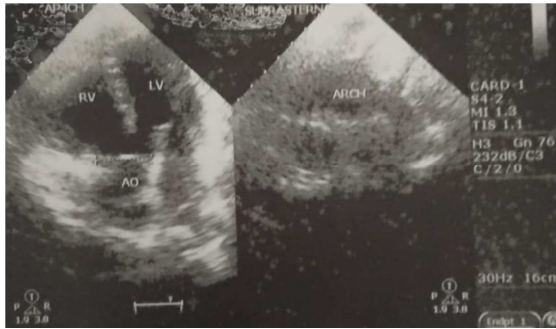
Doppler echocardiography showing TOF with RV-right ventricle, LV-left ventricle, AO- aortic opening, ARCH- aortic arch.
